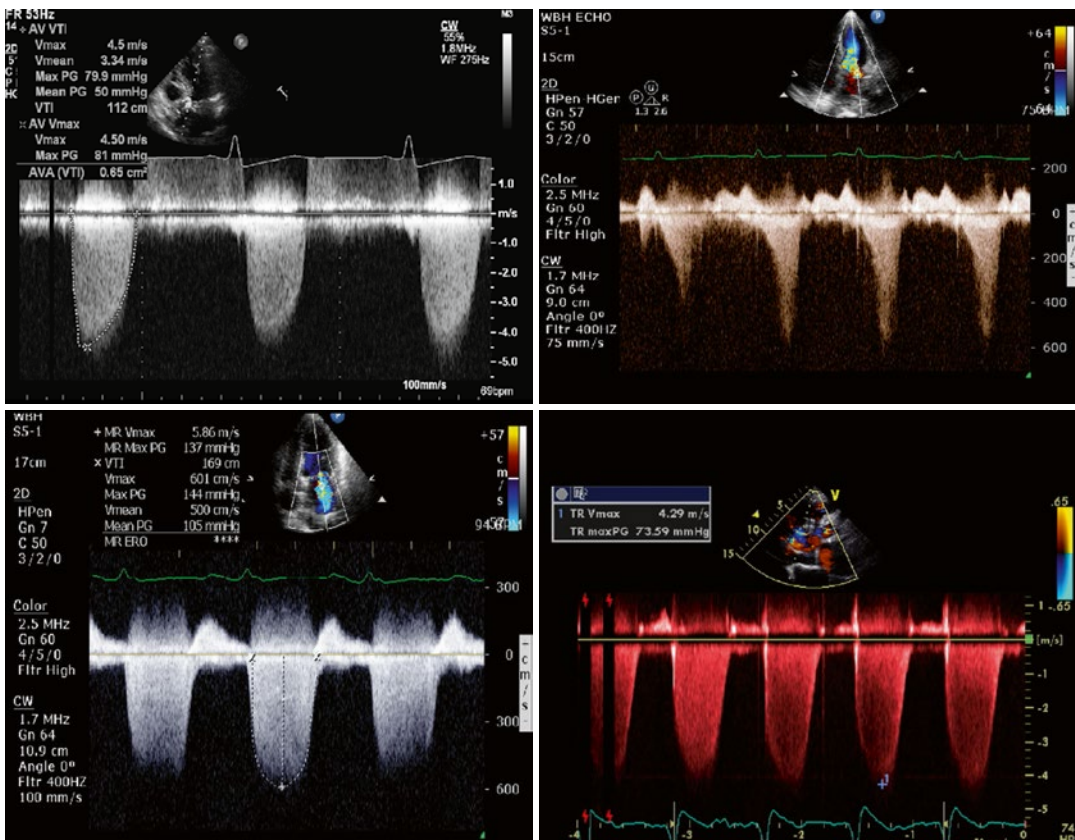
Continuous wave Doppler recordings of aortic stenosis (AS) (top left), mitral regurgitation (MR) (bottom left), tricuspid regurgitation (TR) (bottom right) and hypertrophic cardiomyopathy with LVOT obstruction (HOCM)
